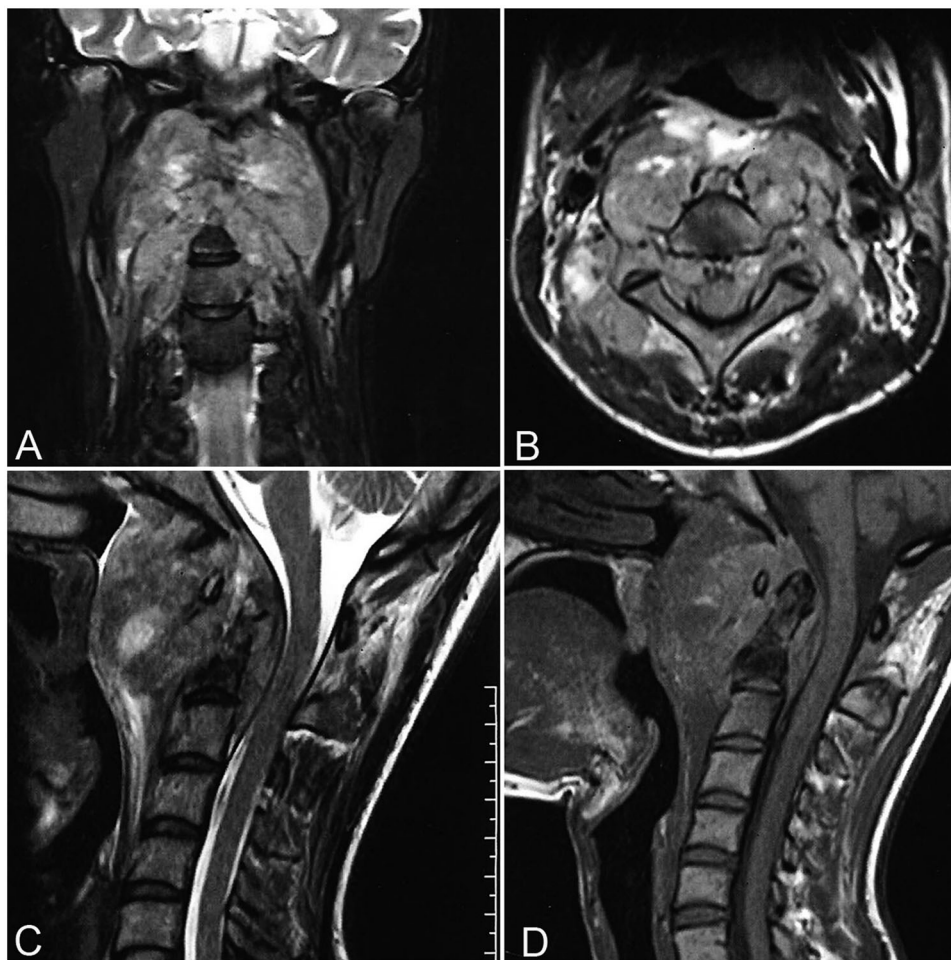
Preoperative coronal (A), axial (B) and sagittal (C) magnetic resonance (MR) T2-weighted images and precontrast MR sagittal T1-weighted image (D) demonstrating a heterogeneous tumor involving the inferior clivus, C1 and C2 vertebrae, the posterior aspect of the pharynx and the vertebral canal.
